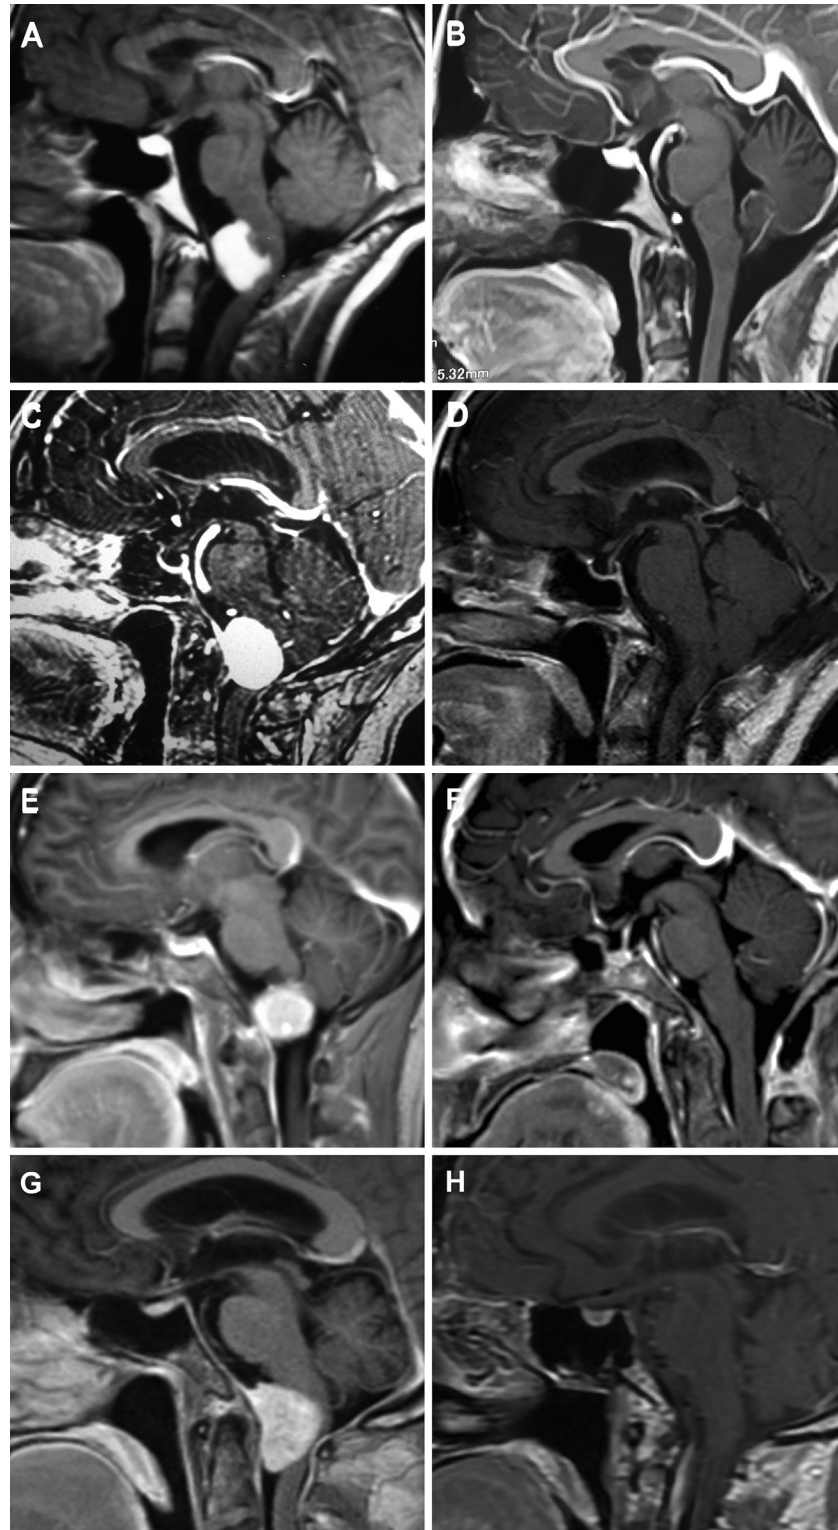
(A–H) Surgical cases. (A, C, E and G) Preoperative T1 enhanced magnetic resonance imaging of foramen magnum meningiomas operated using far lateral
